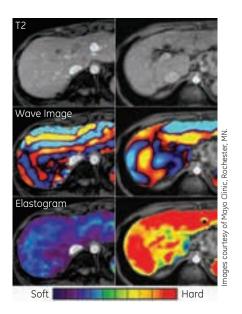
MR elastography is used here to characterize the relative stiffness in soft tissue. Top row: Conventional MR images of two different individuals are not capable of showing the presence or absence of liver fibrosis. Center row: Mechanical waves are generated in the upper abdomen with an acoustic driver device and imaged with a special MRI technique. Bottom row: The wave information is processed to generate "elastograms," showing the stiffness of tissue. The patient on the right has marked elevated tissue, consistent with moderately advanced liver fibrosis. The patient on the left has a normal liver stiffness appearance.
